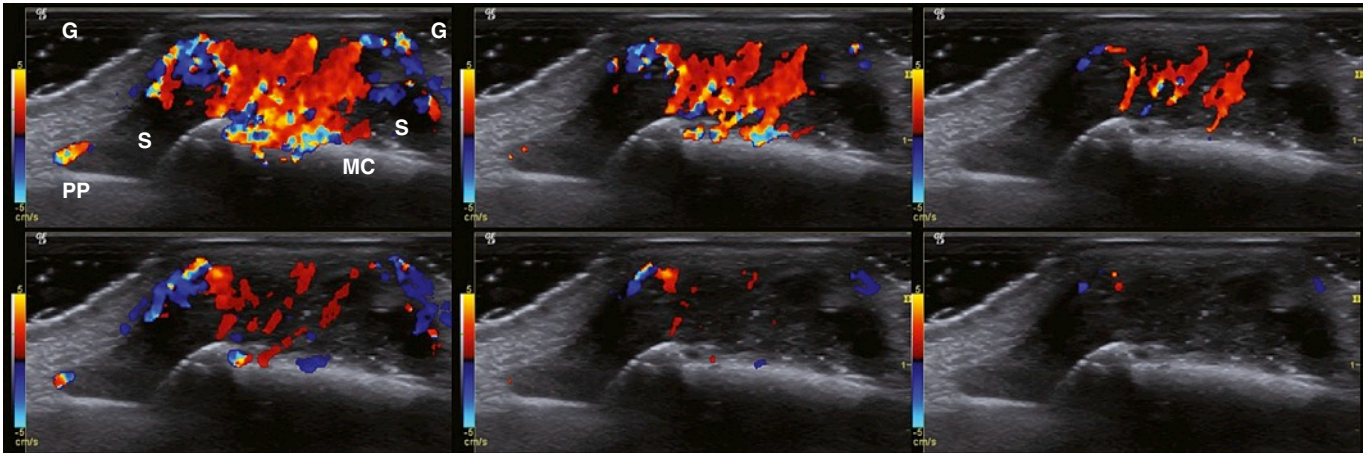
BLOOMING. Longitudinal images of the third metacarpophalangeal joint show massive synovial hypertrophy (S). To obtain good acoustic contact with the convex skin surface, generous amounts of scanning gel (G) have been applied. The joint is subluxated, with volar displacement of the proximal phalanx (PP) relative to the metacarpal bone (MC). *Top images* are from the systole and *bottom images* from the diastole of the same cardiac cycle. The images were stored as Raw Dicom, which allows for offline adjustment of color Doppler gain. The three systolic images and the three diastolic images are therefore temporally and spatially identical. (*Left*) Images were obtained with our routine settings, showing large and confluent areas of color. It is a clear case of blooming, because the color bleeds outside the vessels, which are so small that they cannot be outlined with certainty on the gray-scale image. In the diastole phase, blooming is not as pronounced but definitely present. Notice that the images do not contain noise pixels; all color pixels are generated by flow, not false flow. (*Middle*) Images, The color Doppler gain has been decreased to reduce blooming. The large and confluent area begins to break up into single vessels. However, much true flow has disappeared from the systolic image, as has nearly all diastolic flow. (*Right*) Color Doppler gain has been further decreased, and the systolic vessels are better separated, although blooming still is present. The diastolic flow is virtually gone. Blooming must be accepted as a systematic error that overestimates the size of vessels. Attempts at minimizing blooming remove true flow from the image. (From *Torp-Pedersen S, Terslev L: Settings and artefacts relevant in colour/power Doppler ultrasound in rheumatology. Ann Rheum Dis 2008;67:143-149.*)
